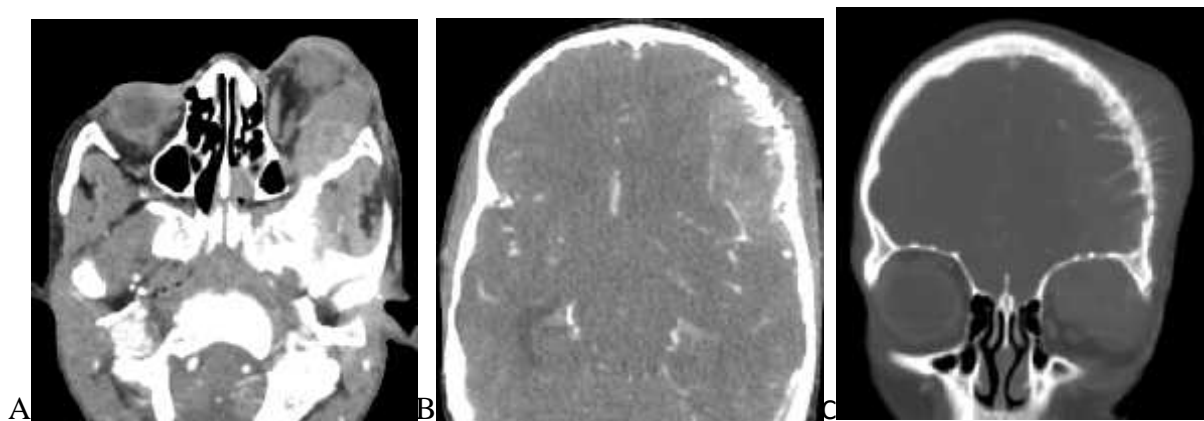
Axial soft tissue window CT images of 10yrs old male patient with neuroblastoma metastasis who presented with left eye proptosis of 1month duration. A)Shows left superior and lateral wall of the orbit huge soft tissue mass causing anterior displacement of the left
